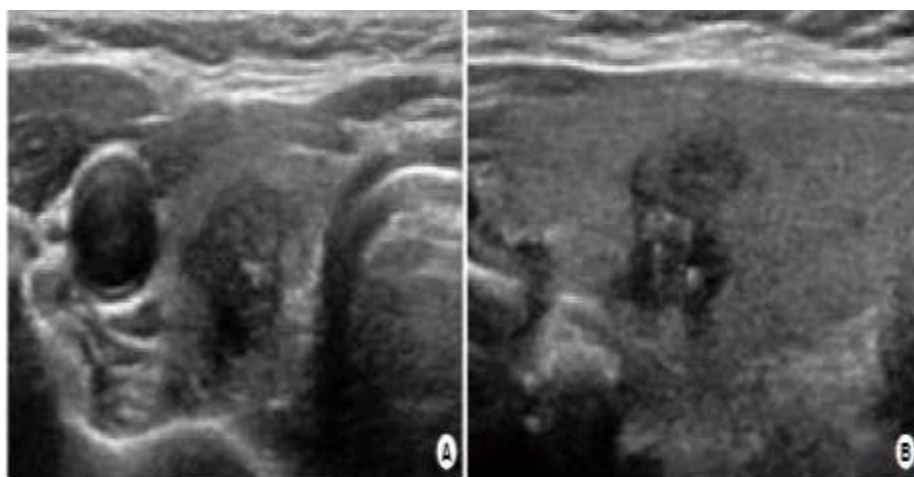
Sonographic features of thyroid malignancy. Source: (Kwak et al., 2011)
